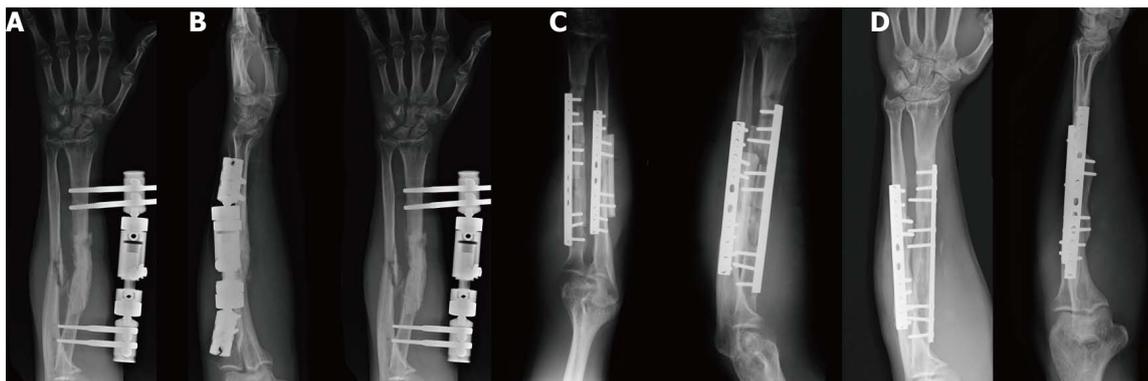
Radiographic aspect of a both radius and ulna non-union in a 25-year-old man. A: Occurred after a Gustilo I open fracture undergone open reduction and internal fixation by plate and screws and intramedullary nailing; B: Once a septic non-union was diagnosed, removal of fixation devices and surgical debridement were performed and an external fixator was applied; C: Eight weeks after the surgical toilette the infection has resolved and thus new synthesis with plate, opposite strut and intercalary bone graft was performed; D: At follow-up both non-unions appear healed with noticeable remodelling of the bone graft.
